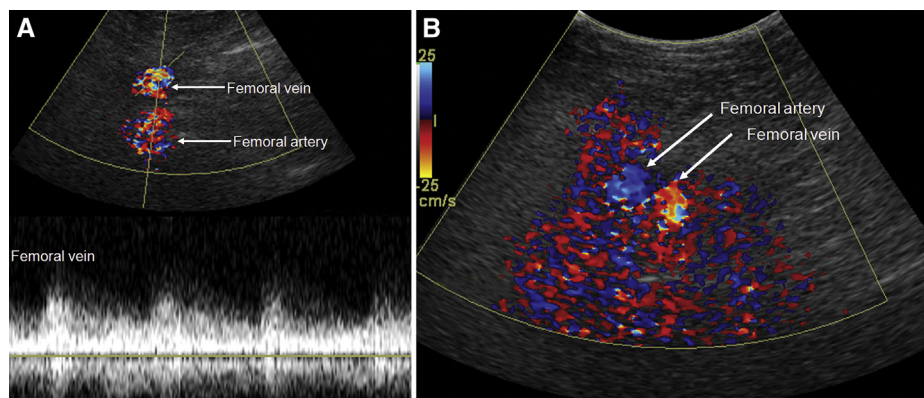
(A) Femoral arteriovenous fistula (AVF); spectral colour-Doppler imaging of the femoral vein, showing mixed high (arterial) and low vascular flows (venous) compatible with AVF. (B) AVF; colour-Doppler imaging of the same patient, showing the typical appearance of mosaic colour pattern, that is, vibration artifacts in the perivascular soft tissue, which indicates the presence of AVF. This figure is available in colour online at <http://carjonline.org/>.
